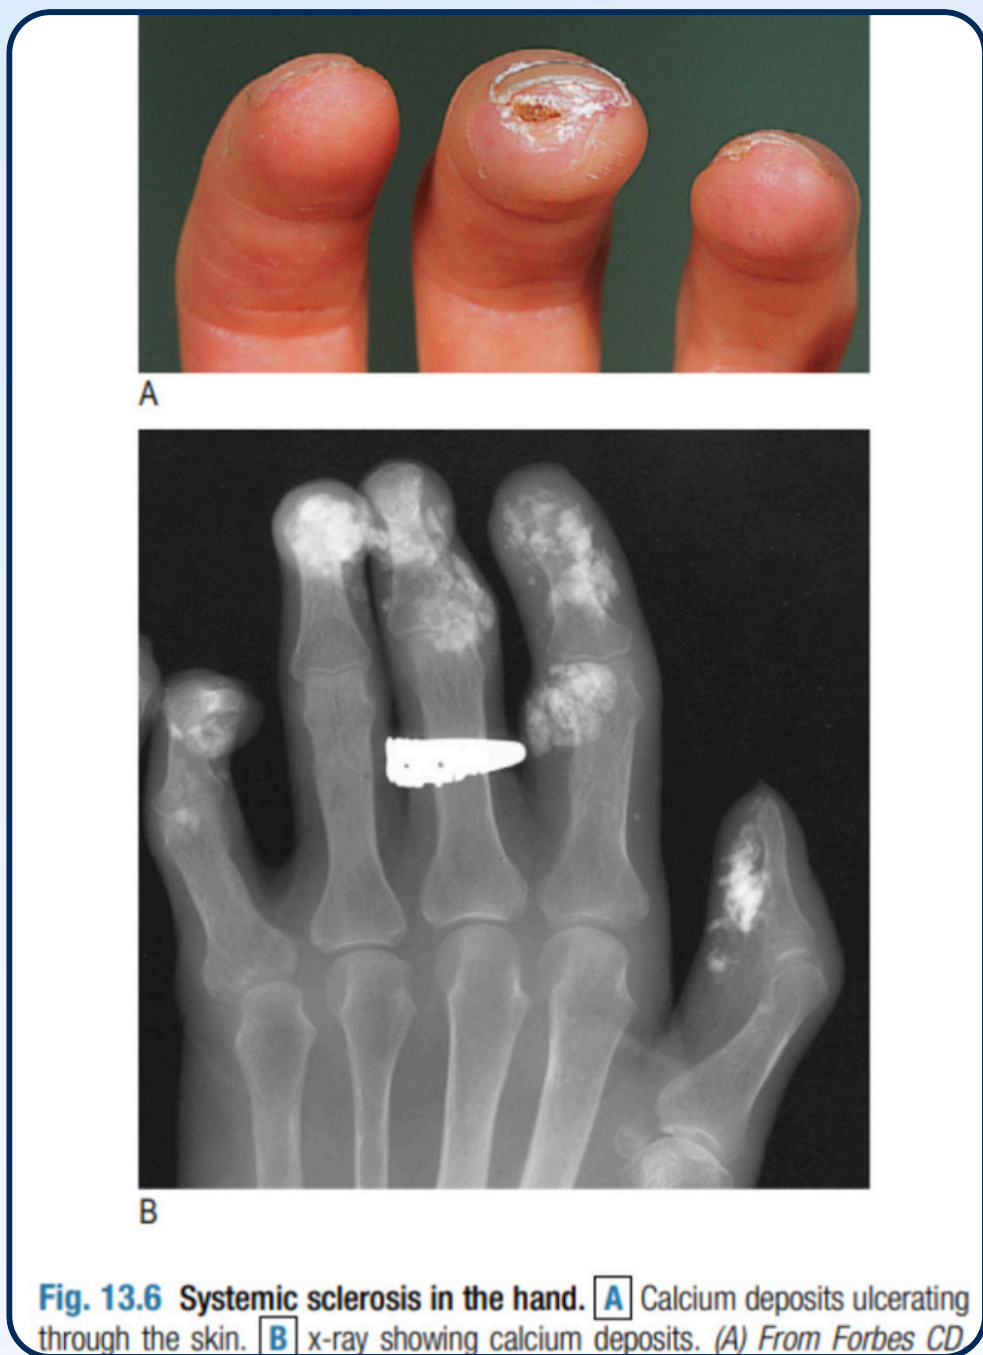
Systemic sclerosis in the hand. A Calcium deposits ulcerating through the skin. B x-ray showing calcium deposits. (A) From Forbes CD
